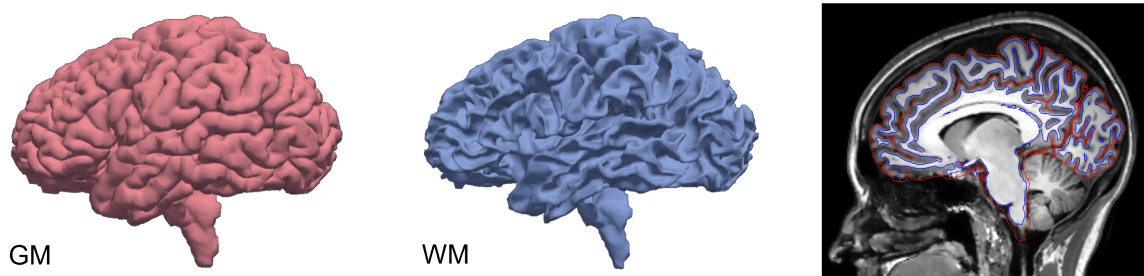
Example of GM (pink) and WM (blue) cortical surface reconstructions. Both surfaces are also displayed within the corresponding brain MRI (right).
